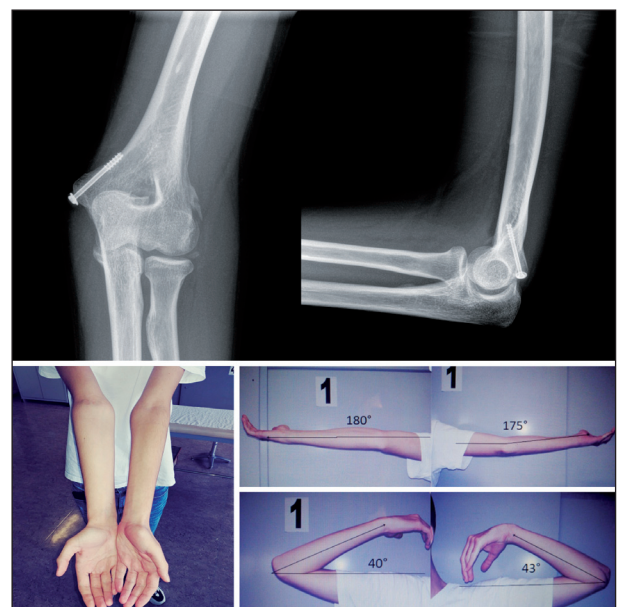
X-rays and clinical evaluation 90 days after surgery.
